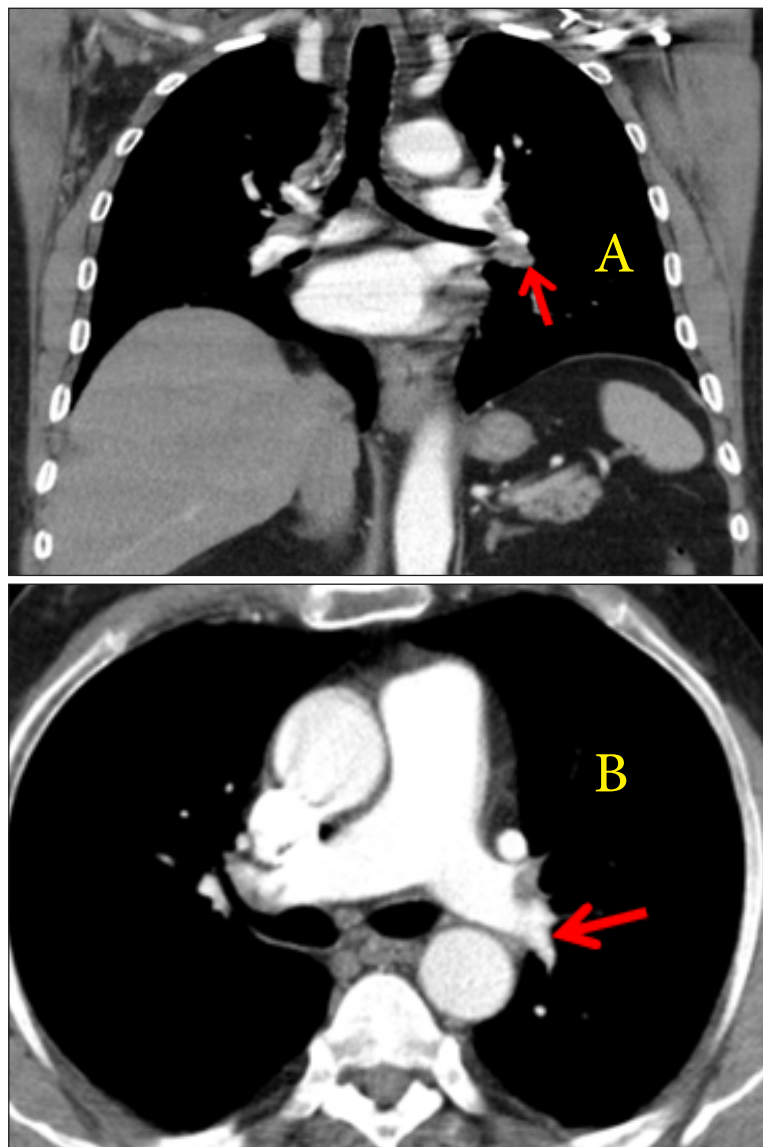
A. Computed tomography angiography (CTA) in coronal section showing an embolus in distal peripheral of the left main pulmonary artery (LMPA) with extension to left upper lobe (LUL), left lower lobe (LLL) (filling defect, red arrow). B. CTA in axial view showing an embolus in distal peripheral of the left main pulmonary artery (LMPA) (filling defect, red arrow).
